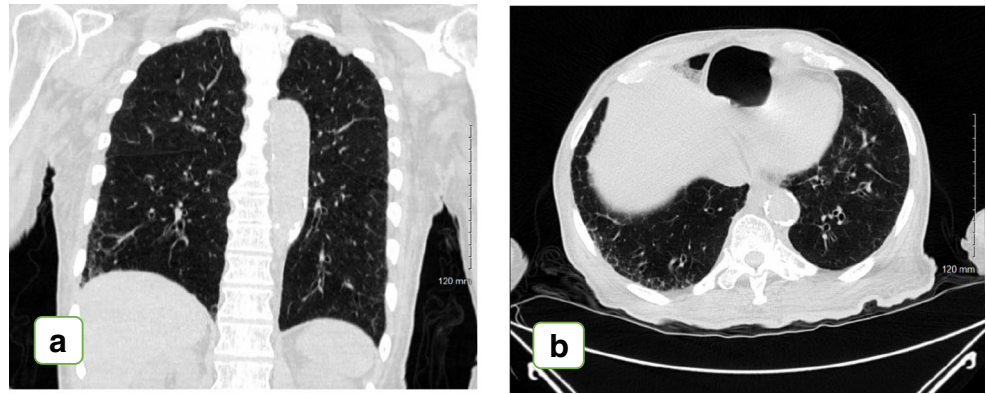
Typical usual interstitial pneumonia. CT image demonstrating peripheral and basilar severe honeycombing, with architectural distortion and traction bronchiectasis
